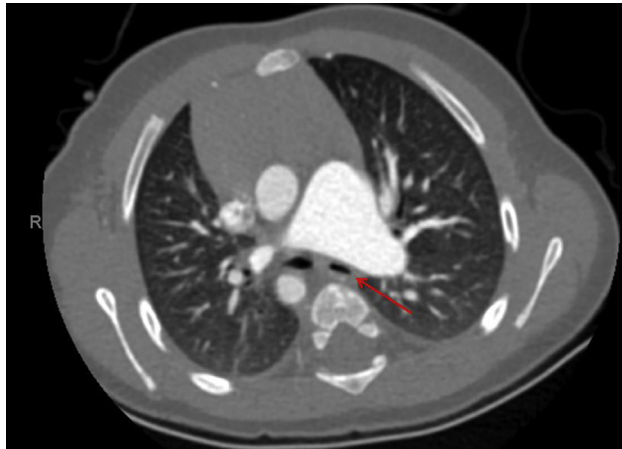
Computed tomography scan showing severely dilated branch pulmonary arteries and compression of airways (arrow).
